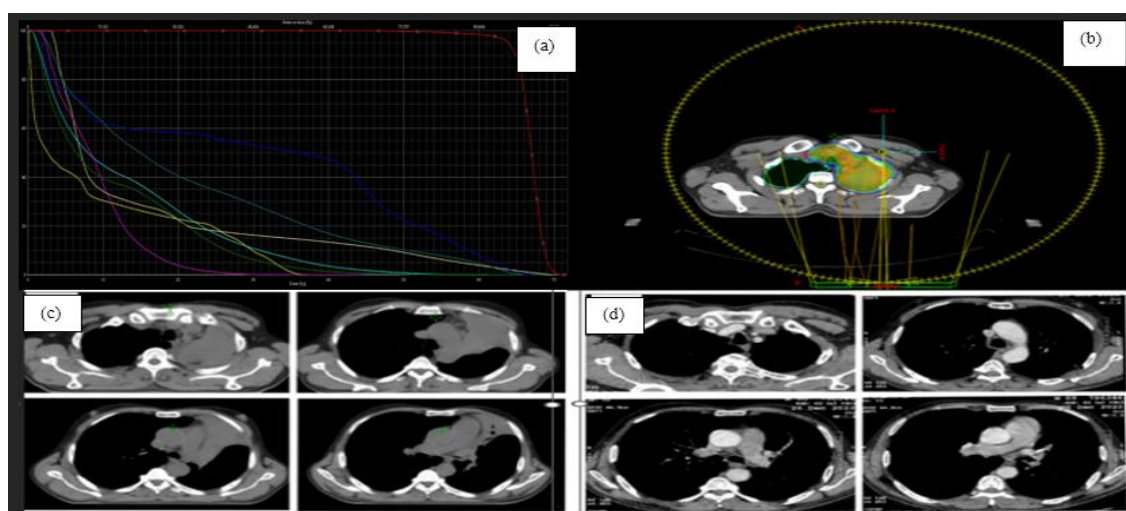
Dose volume histogram (DVH) (a) and Dose colour wash, field arrangement (b) and Pre-CRT (c) and post-CRT (d) axial CT slices
